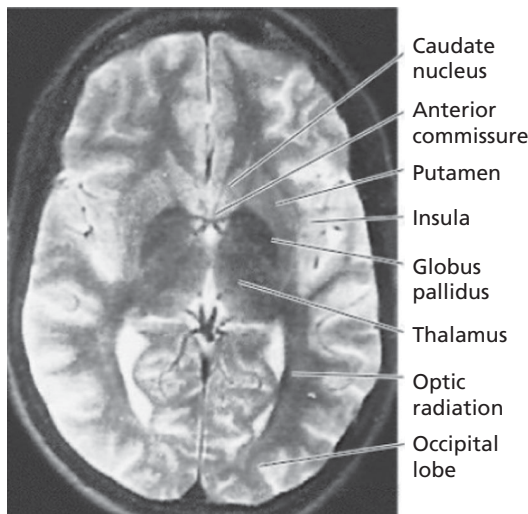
MRI of the horizontal section of the head.
